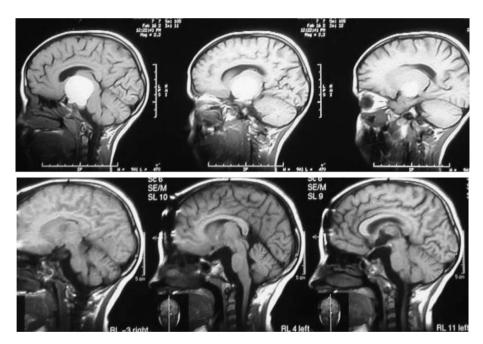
Case 3: T_1 -weighted MRI before surgery and 2 years after the total resection.
